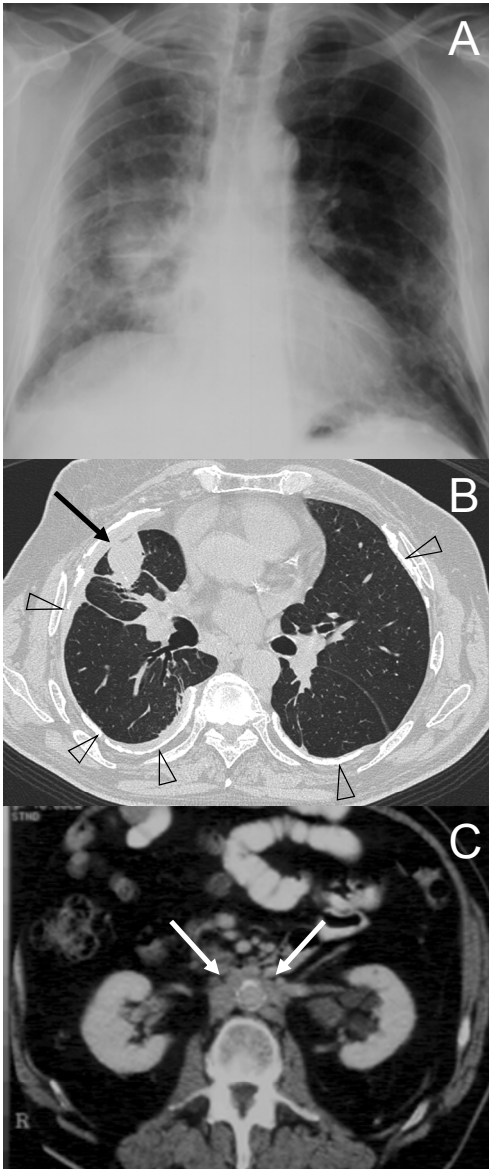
(A) Chest radiograph taken in 1998 showing intense profusions suspected of being partially parenchymal and pleural thickening. (B) Chest high resolution computed tomography (HRCT) taken in 2002 showing bilateral partly calcified diffuse pleural thickening (arrowheads) with rounded atelectasis (black arrow). (C) Abdominal CT scan taken in 1994 showing a para-aortal thick fibrous mass.
